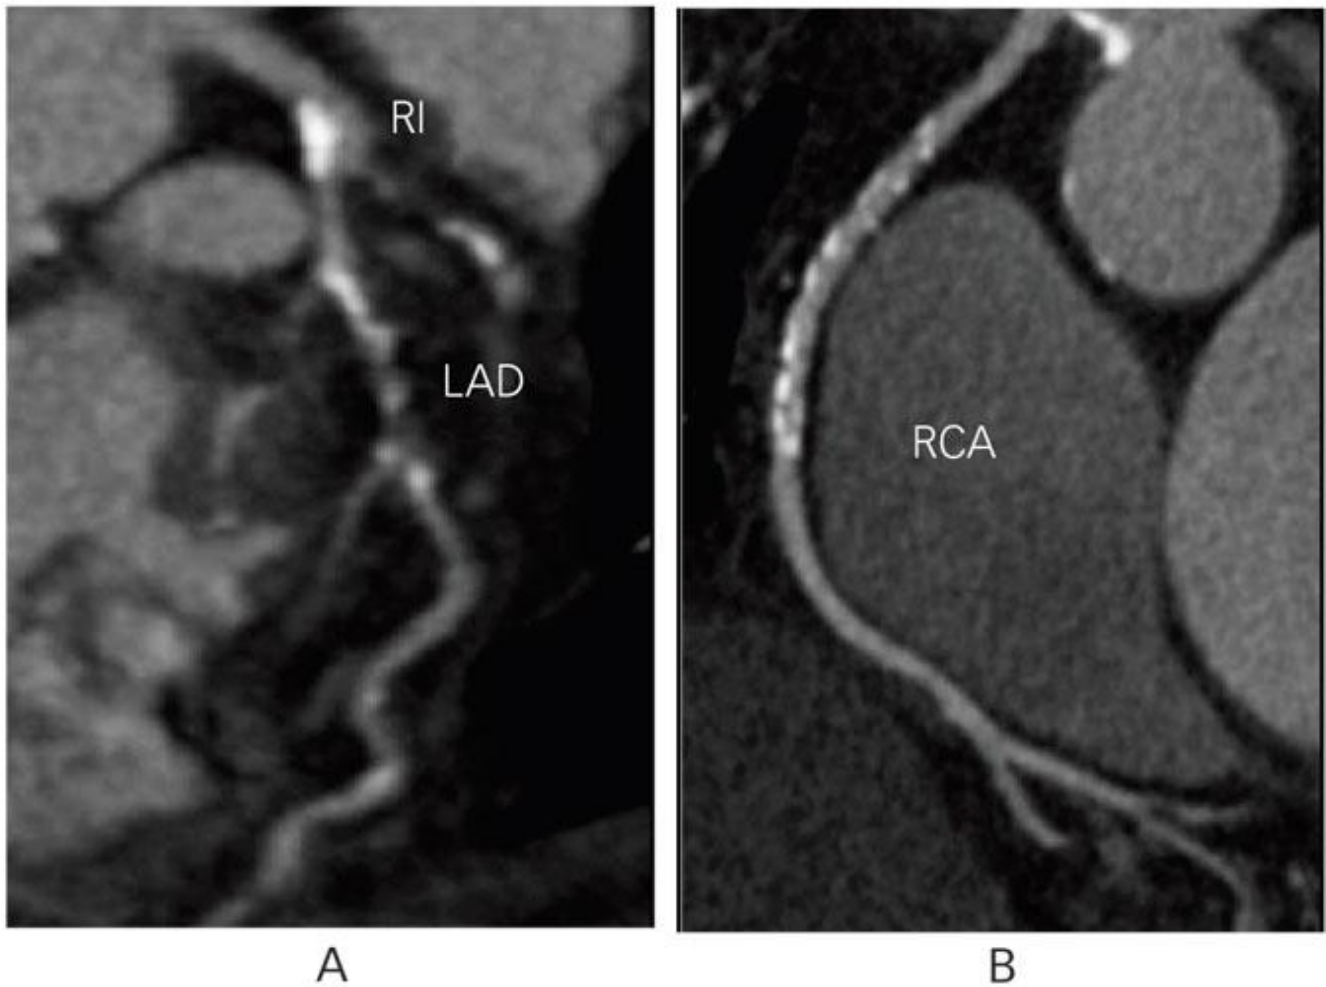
64-Slice CT angiogram showing severe obstructive disease with noncalcified and calcified plaques in the left anterior descending and ramus intermedius coronary arteries (A). Nonobstructive disease with calcification in the right coronary artery is visible (B).
